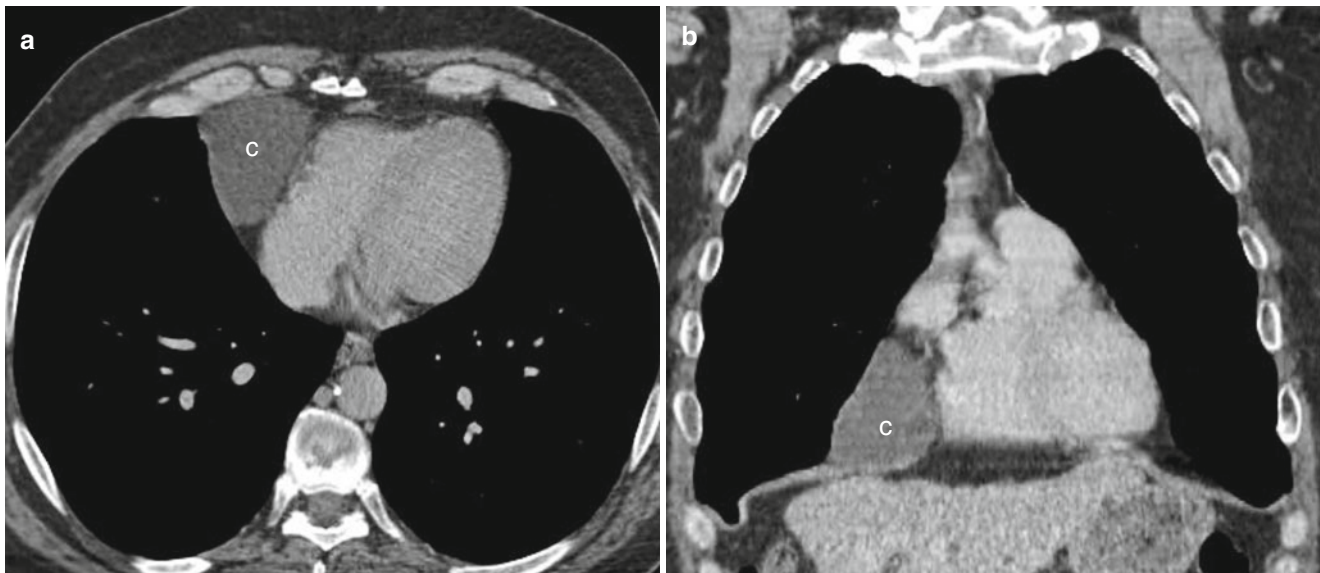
Pericardial cyst in a 56-year-old man with incidental discovery of a cardiophrenic mass on a chest radiograph. Panel (a), an axial scan, and panel (b), a coronal view, show a well-defined, right cardiophrenic
